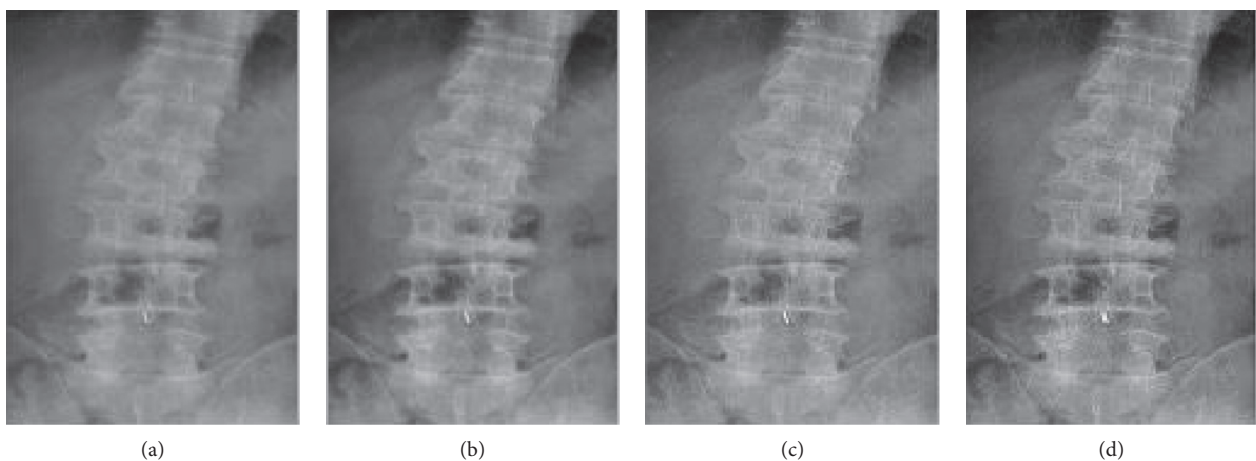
X-ray images of a patient. (a) Original algorithm. (b) Eight-direction Sobel. (c) The improved eight-direction Sobel. (d) The algorithm in this study.
